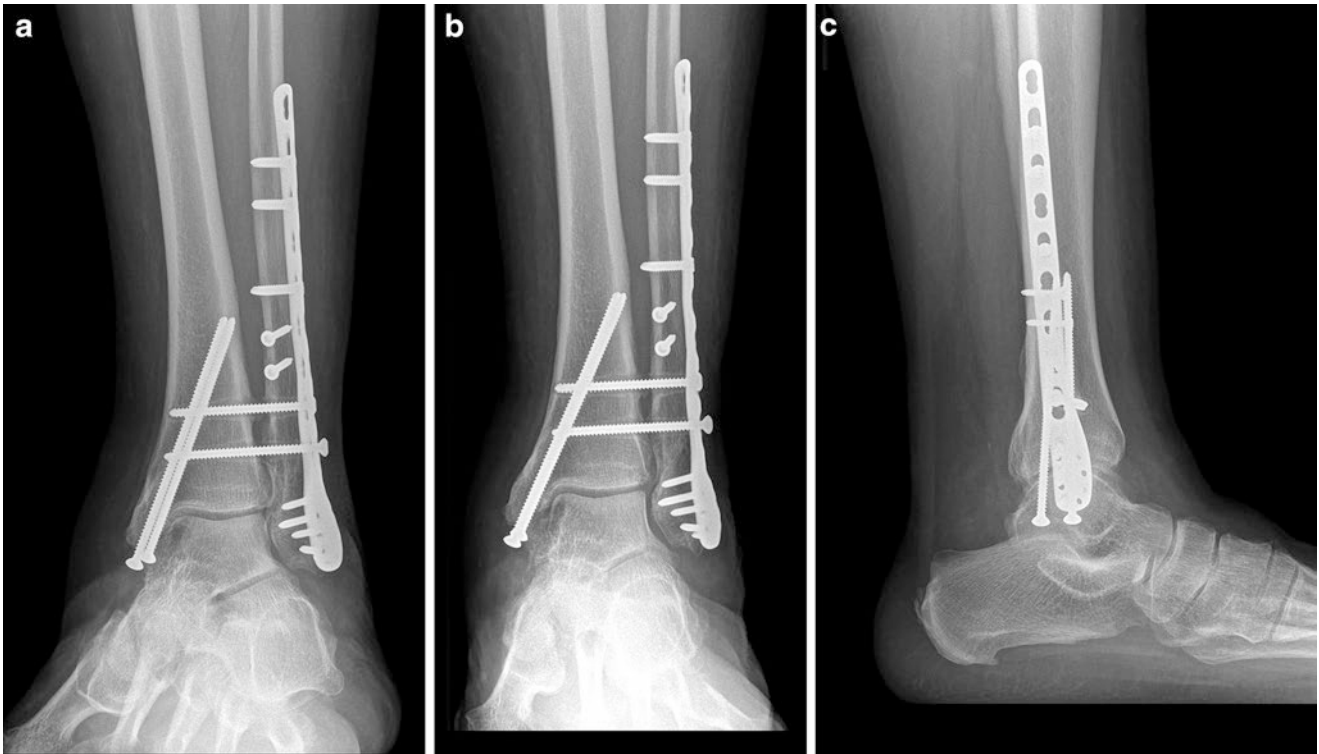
Anterior-posterior (a), mortise (b), and lateral (c) ankle conventional radiographs 1-year postoperative follow-up demonstrating ankle mortise joint spaces maintained without early onset of posttraumatic arthritis
